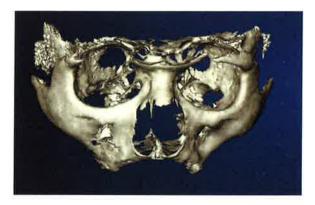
CT-generated 3-D image demonstrating severe maxillary alveolar bone loss.
